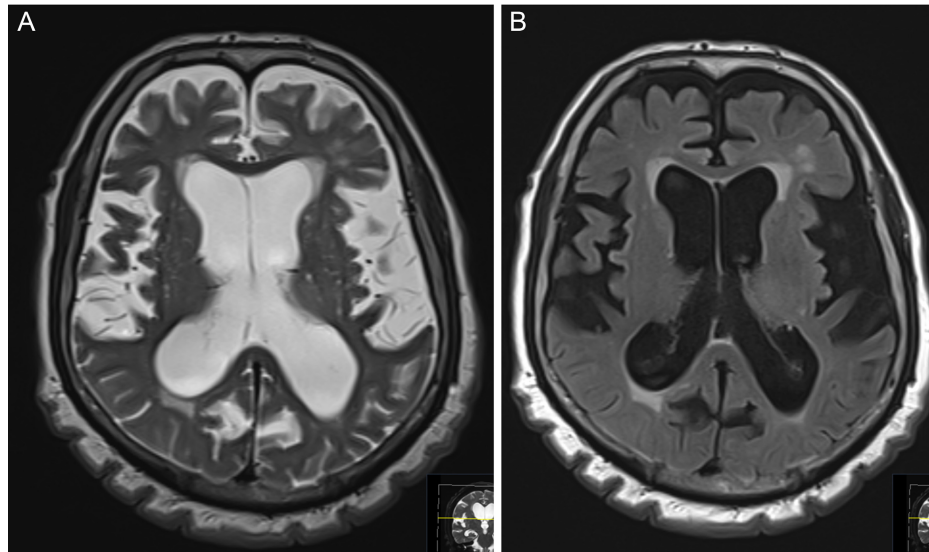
Axial T1- and T2-weighted magnetic resonance images reveal coexistence of both cutis verticis gyrata and normal pressure hydrocephalus.
